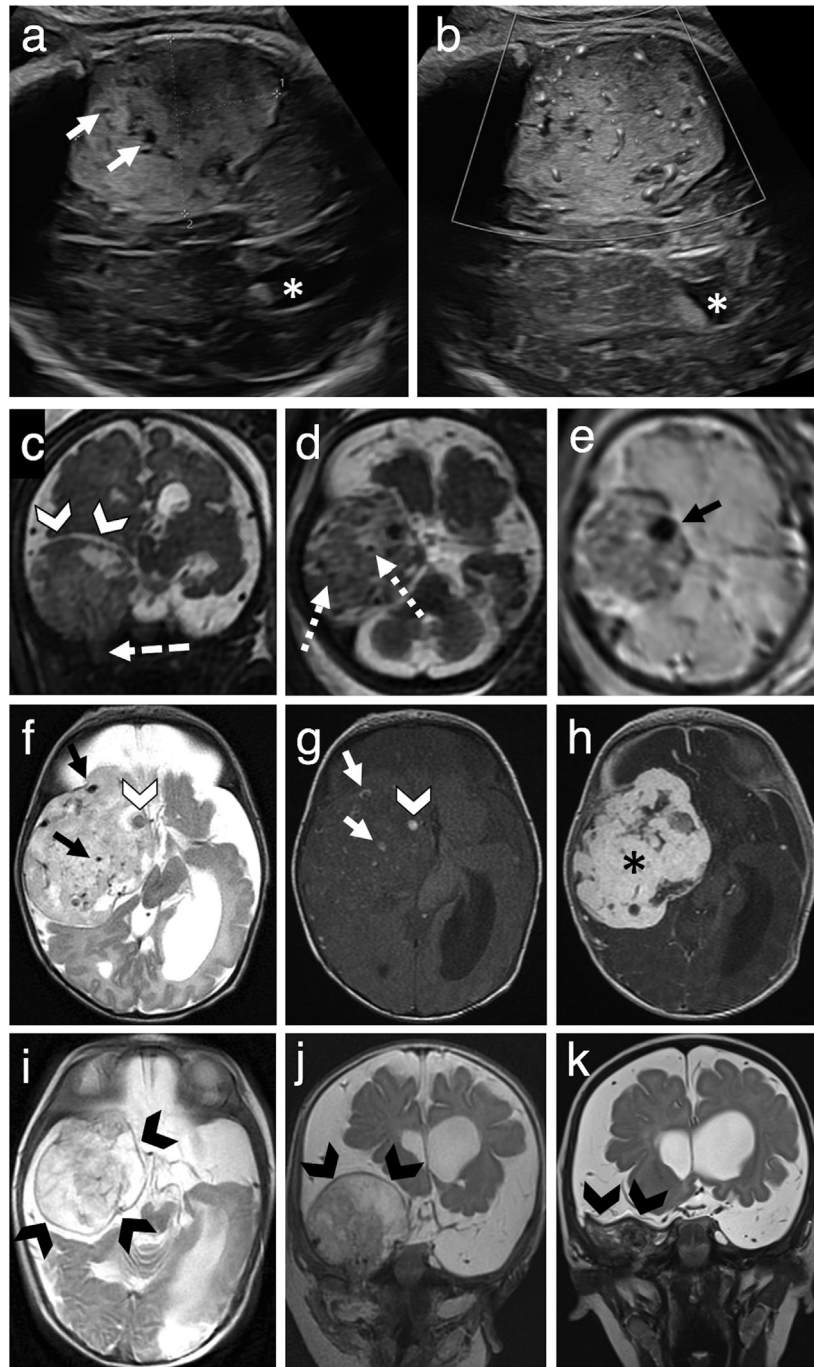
(a) Fetal US at 33 weeks of gestation showing a well-defined hyperechoic right supratentorial mass, with small hypoechoic foci (*white arrows*) corresponding to the vascular structures at color Doppler. (b) The tumor generated compression of the right lateral ventricle and left ventricular dilatation (*asterisk*). (c, d, e) Fetal MRI. Coronal and axial SE-T2-weighted planes demonstrated an extraparenchymal topography of the tumor (*arrowheads*), with an extracranial infratemporal extension (*large dotted white arrow*). In the transverse plane, the well-defined tumor had a heterogeneous intermediate signal on SE-T2 (d), with low signal curvilinear vascular structures (*small dotted white arrows*) on SE-T2 and focal hemorrhagic low signal foci on GE-T2 (e, *black arrow*). (f, g, h) Postnatal MRI at day 1 of life. Axial SE-T2- and T1-weighted planes showed low T2/high T1 vascular structures (*arrows*) and one high T1 hemorrhagic focus (*arrowhead*) within the tumor. Axial SE-T1-weighted after intravenous administration of gadolinium demonstrated heterogeneous and intense contrast enhancement of the tumor (h, *asterisk*). (i, j) Follow-up MRIs at age 2 months. Axial and coronal T2-weighted planes demonstrated global size reduction (*black arrowheads*) with the regression of vessels size within the tumor. (k) At the age of 7 months, coronal T2-weighted images showed progressive involution of the right temporal fossa tumor (*black arrowheads*).
